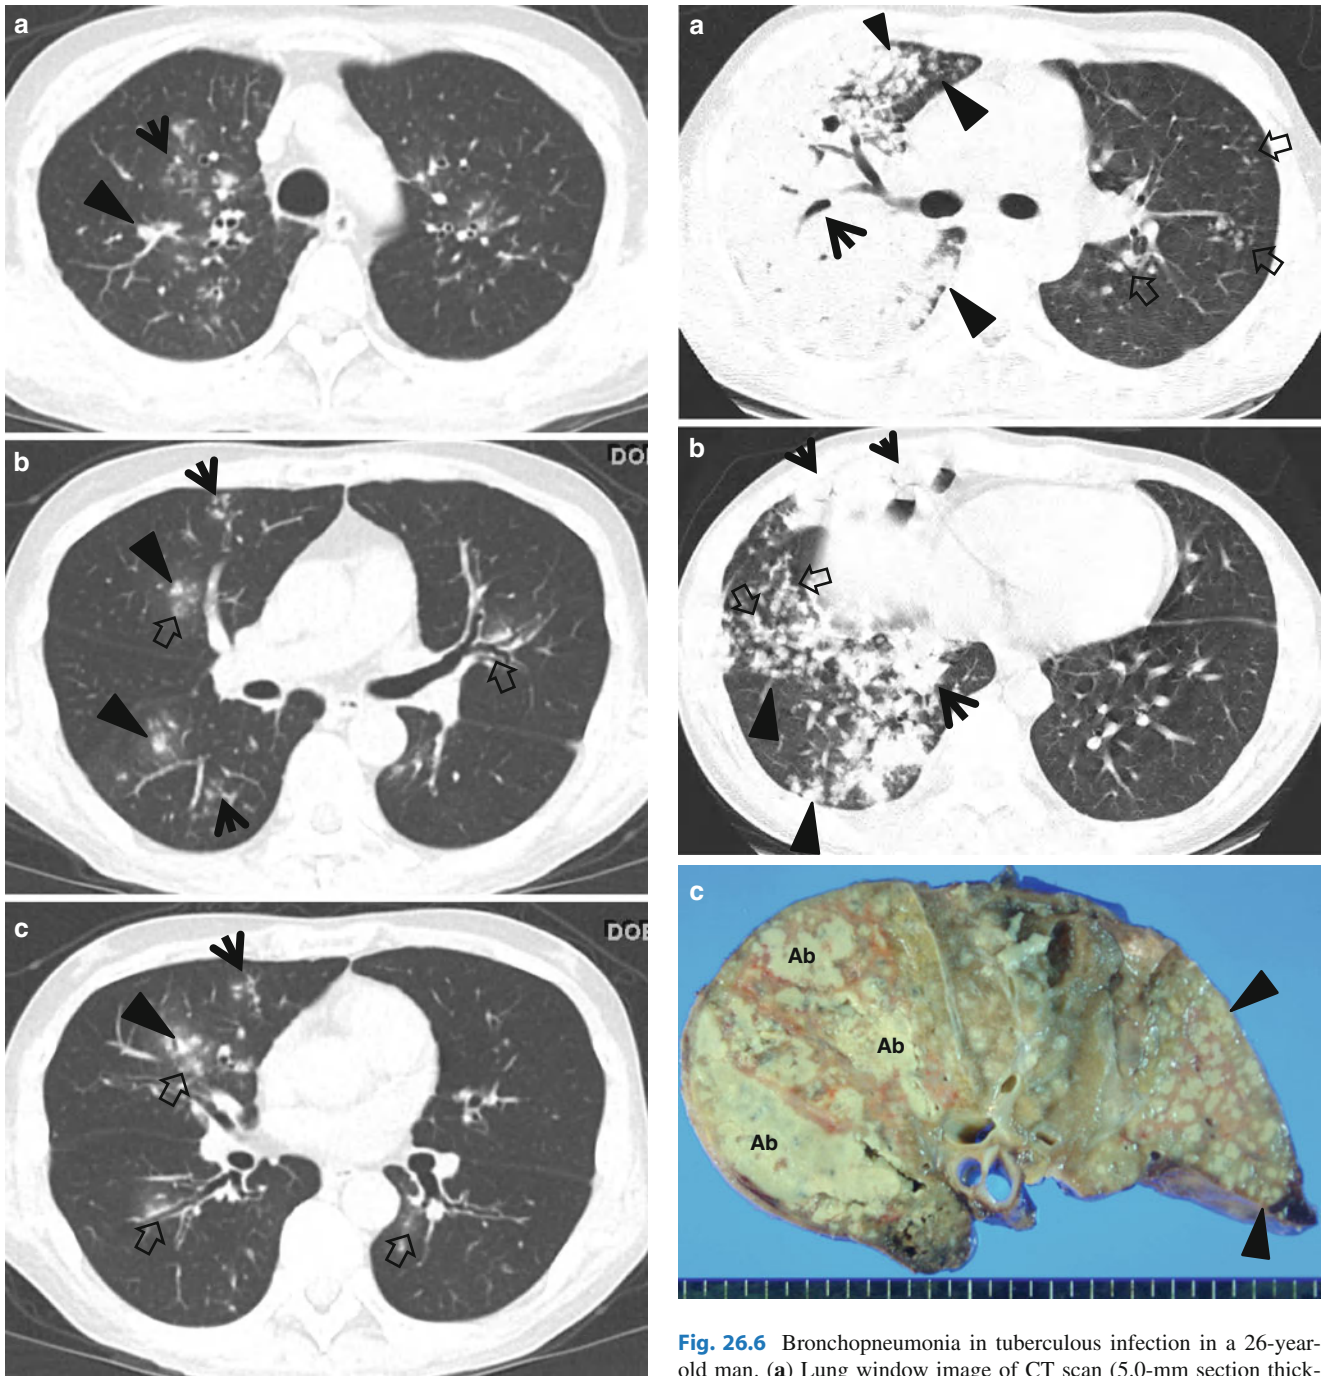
Mycoplasma pneumoniae* pneumonia in a 29-year-old man who received hematopoietic stem cell transplantation owing to acute myeloid leukemia. (a–c) CT scans (2.5-mm section thickness) obtained at levels of aortic arch (a), bronchus intermedius (b), and basal trunks (c), respectively, show lung abnormalities comprising tree-in-bud signs (arrows), small nodules (arrowheads) and ground-glass opacity lesions (open arrows) in both lungs. Please note involvement of both central and peripheral portions of lungs
